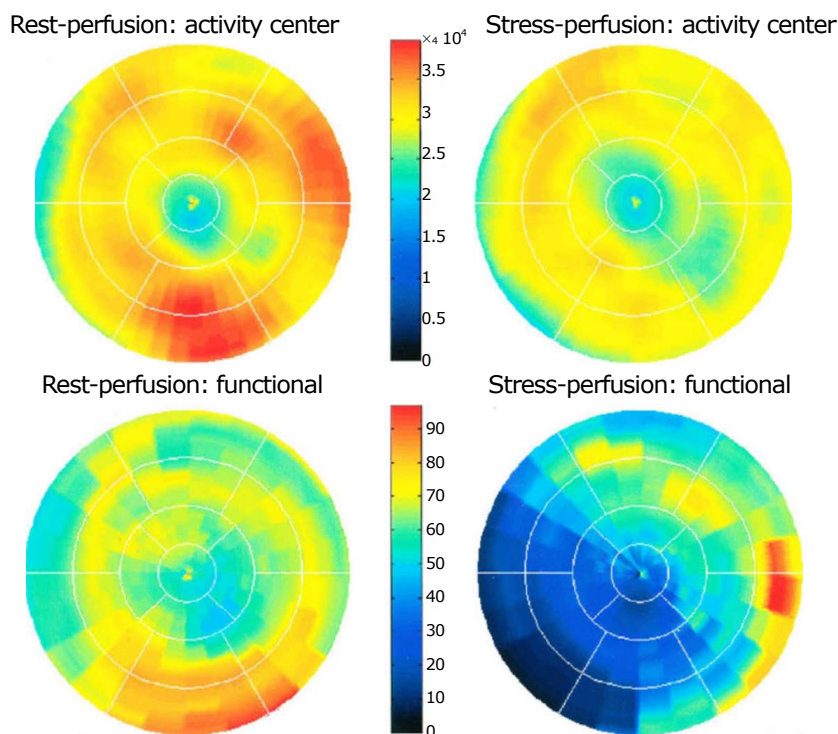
Positron emission tomography computed tomography scanning demonstrating normal findings on the rest ¹³N-ammonia polar map (left panel) and normal perfusion on adenosine ¹³N-ammonia polar map (right panel). Myocardial perfusion was assessed at rest and during vasodilator pharmacological stress induced by adenosine, using 400 MBq of ¹³N-ammonia as the perfusion radiotracer.
